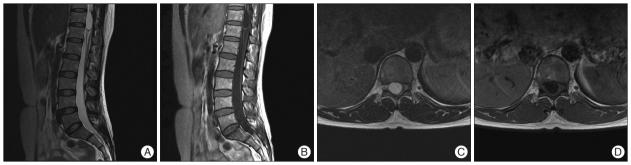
The magnetic resonance image revealing a well-defined cystic lesion on the ventral side of the spinal cord at the T11 to T12 levels. The lesion is a 36×15 mm oval intramedullary cystic mass. The lesion is hyperintense in T2-weighted images (A and C) and hypointense in T1-weighted images (B and D). In the axial imaging, the cyst is observed to compress the spinal cord on the left dorsal side (C and D).
